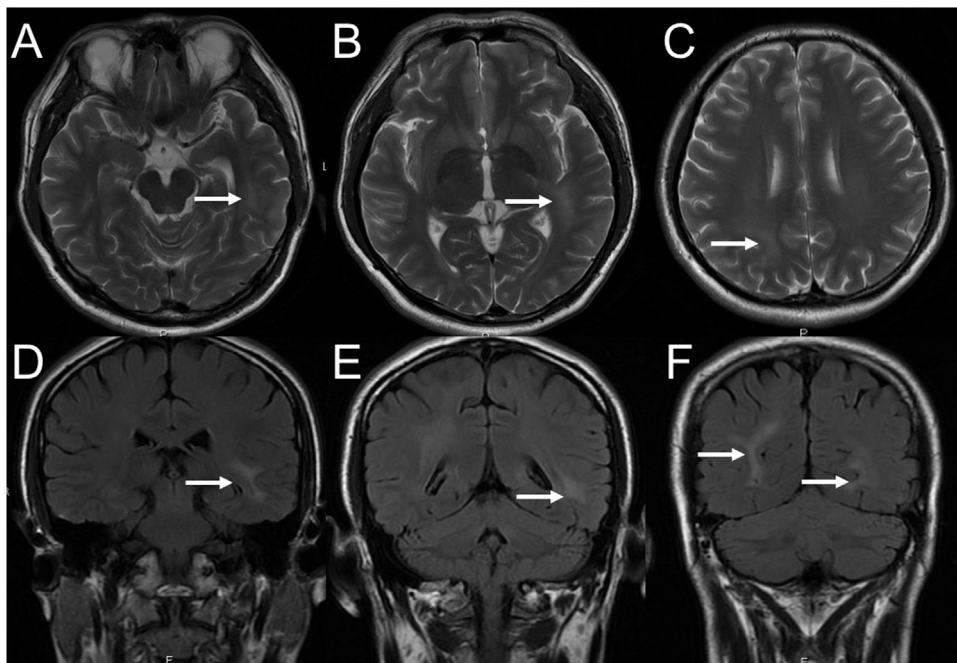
Brain MRI in April 2015 showing diminution of the hyperintense T₂ and T₂ FLAIR lesion compared with the brain MRI in March 2015.
